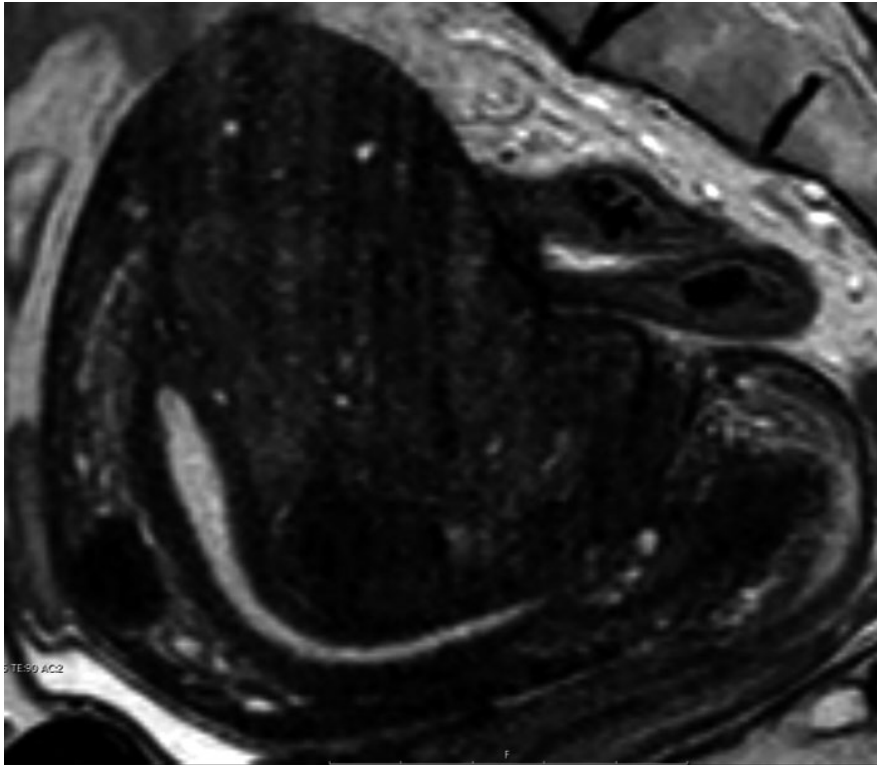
Sagittal T2 W MRI showing clear posterior and anterior wall asymmetry due to focal adenomyosis (and several leiomyomas)
